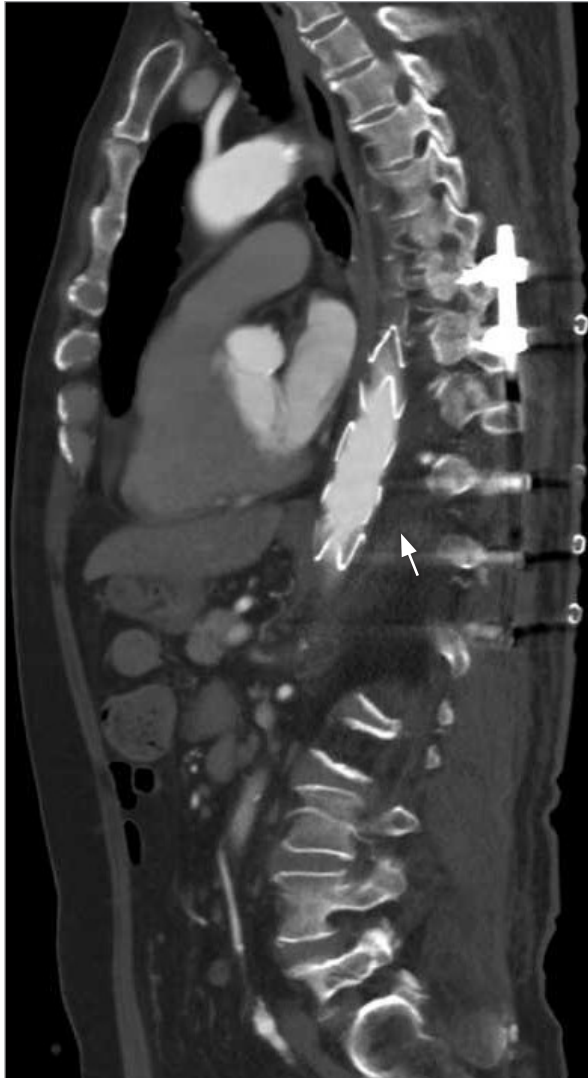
Posttreatment computed tomography image revealed that the aorta in the area compressed by the thoracic vertebra (arrow) was protected and dilated by the stent graft.
